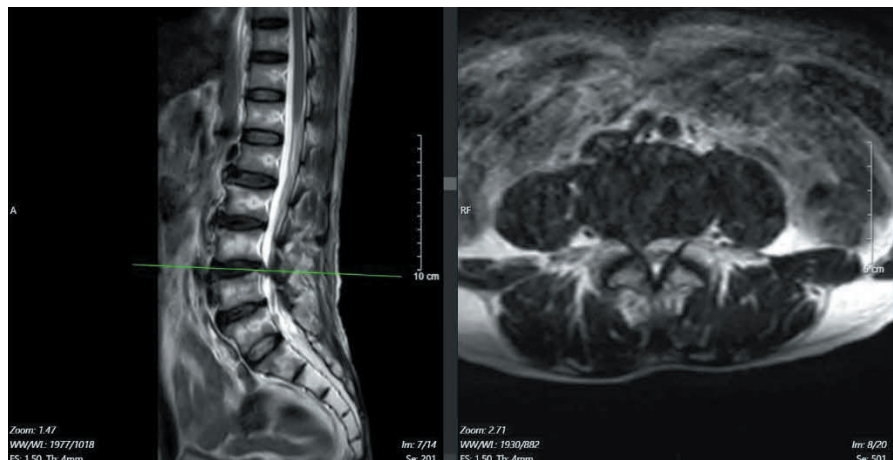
MRI images of the lumbar spine on December 27, 2024: Right paracentral disc protrusion at L3/4.
